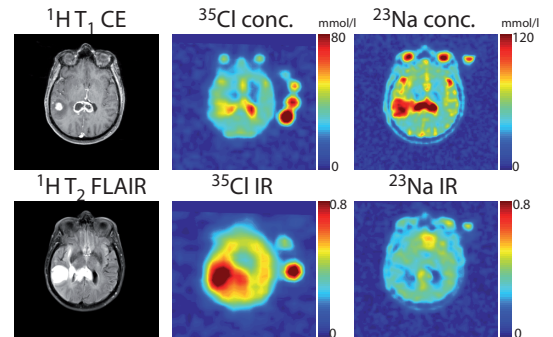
Glioblastoma (WHO $^{\circ}\text{IV}$) of the right temporal lobe and the corpus callosum. ^{23}Na conc. MRI revealed elevated signal intensity in all parts of the tumor, whereas ^{23}Na IR showed parts with reduced and increased signal intensities. Slightly increased signal intensities are also visible in ^{35}Cl conc. MRI. In contrast to ^{23}Na IR imaging, ^{35}Cl IR MRI revealed a strong signal increase in the affected brain region.
